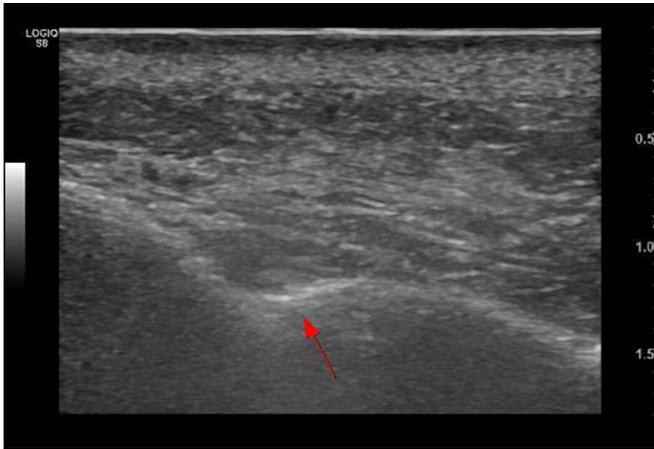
Ultrasound guided infraorbital nerve blockade. Arrow indicates the infraorbital foramen.
